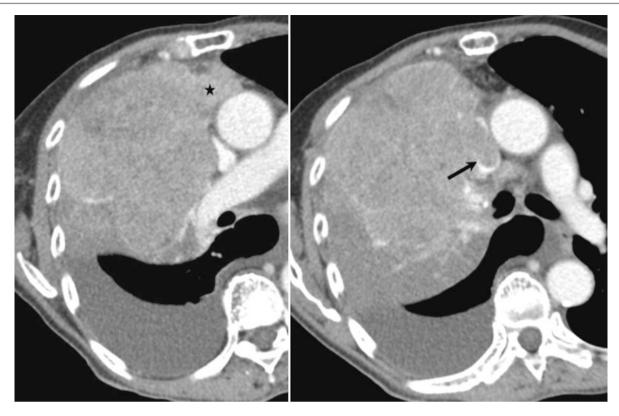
A 70-year-old man with small cell cancer. Contrast-enhanced axial CT images show a large right upper lobe mass with mediastinal invasion (asterisk) and extension in the superior vena cava (arrow)
